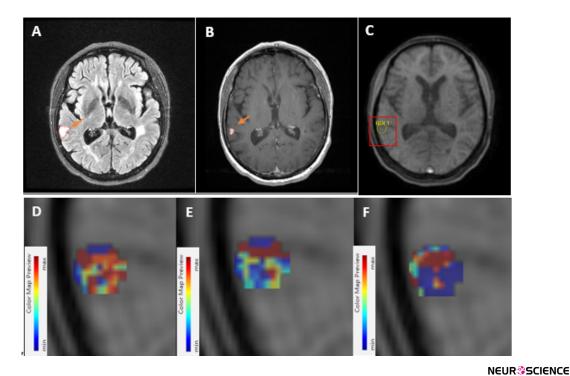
Enhanced lesion in T2-FLAIR, Pre-contrast T1, and DCE-T1 in A, B, and C respectively
